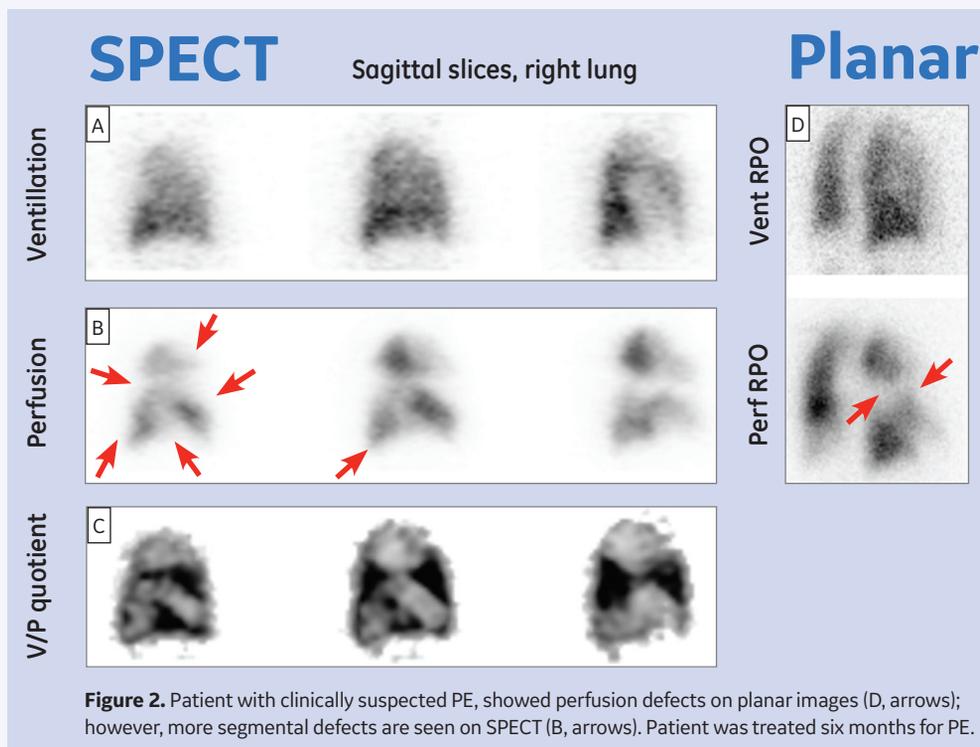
Patient with clinically suspected PE, showed perfusion defects on planar images (D, arrows); however, more segmental defects are seen on SPECT (B, arrows). Patient was treated six months for PE.
